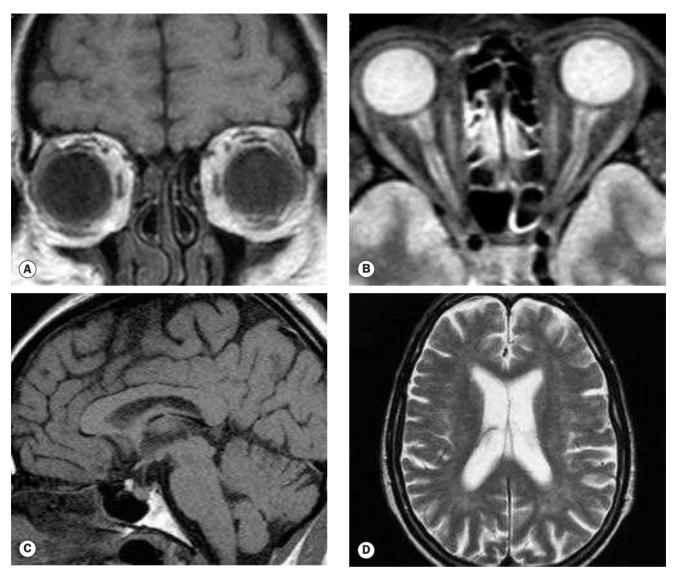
MR scans. (A) T1-weighted coronal image through the globe in which vitreous is hypointense (dark) and orbital fat is hyperintense (bright); (B) T2-weighted axial image in which vitreous and cerebrospinal fluid (CSF) are hyperintense; (C) T1-weighted midline sagittal image through the brain in which the CSF in the third ventricle is hypointense; (D) T2-weighted axial image through the brain in which the CSF in the lateral ventricles is hyperintense
